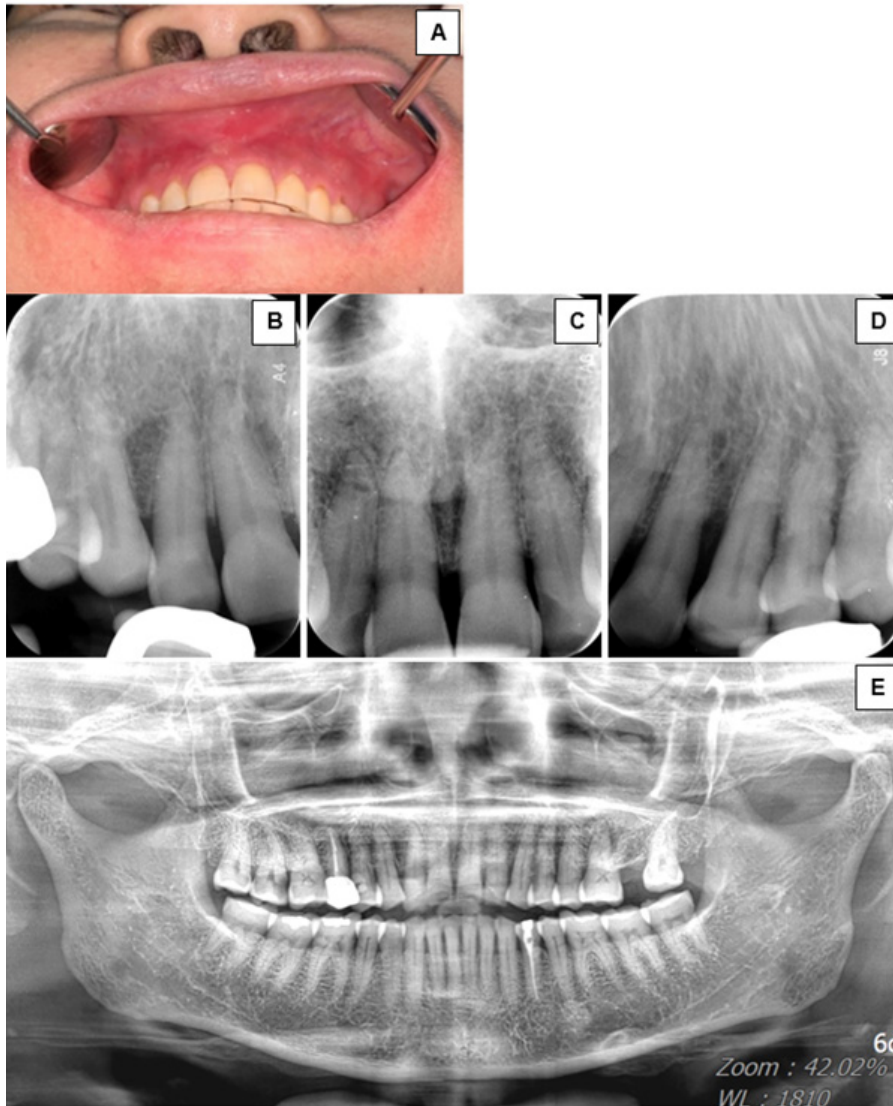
Clinical presentation on first visit; A) upper vestibular area B) upper right C) middle D) upper left E) panoramic radiograph on first visit
